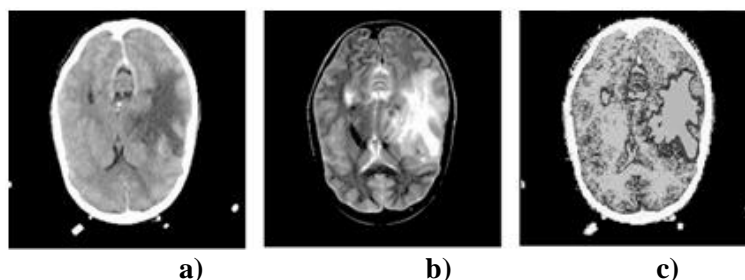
6 Fused image using the K -means algorithm for different classes of tissue: a) reference CT image, b) registered MRI image of the same patient, and c) fusion result [53].
